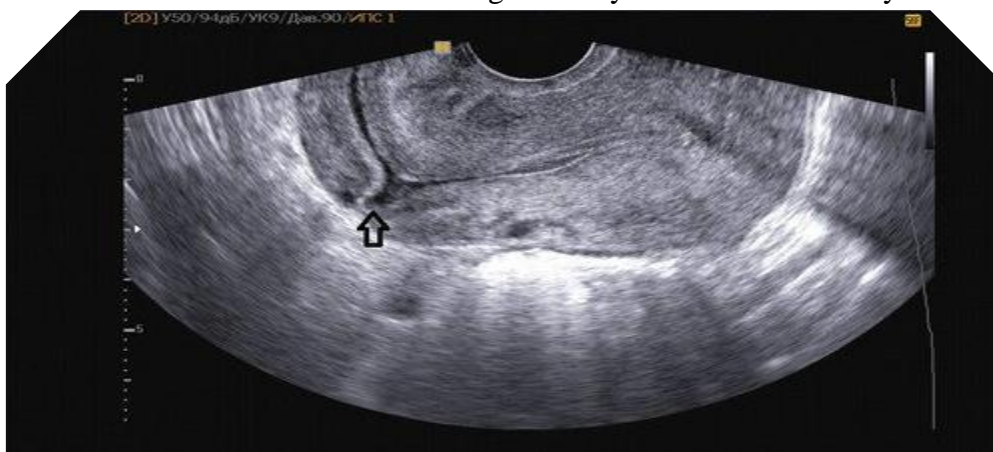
A "shelf" ("niche") symptom in ultrasound.
